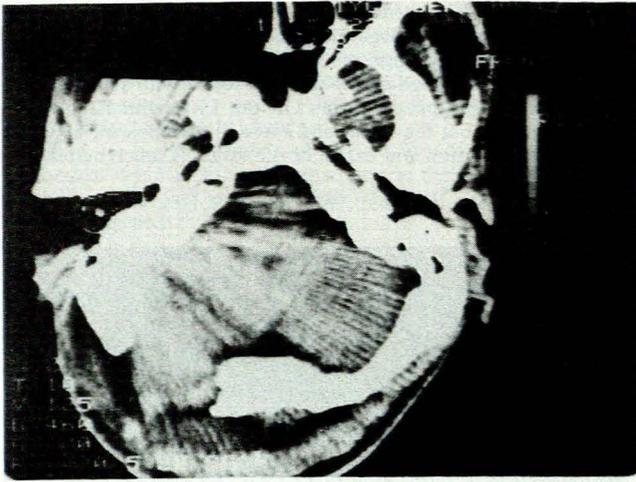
CT scan of the posterior fossa. The image is of no diagnostic value owing to an artefact arising from a BIPP plug in the left mastoid region.
